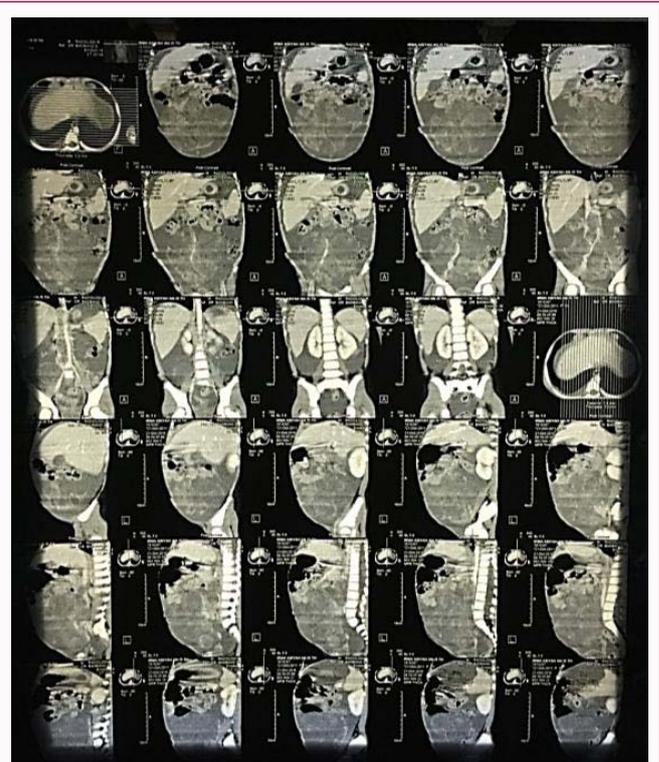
Abdominal CT showing solid mass from the internal genitalia (ovary).
